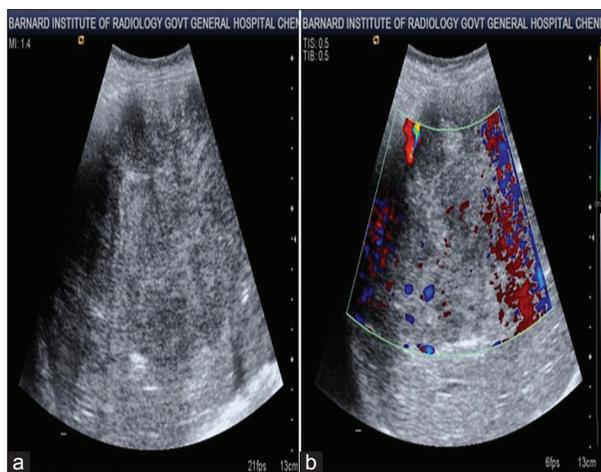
(a and b) Conventional gray-scale ultrasonography - large hyperechoic lesion noted involving both lobes of the liver. Typical hemangioma
